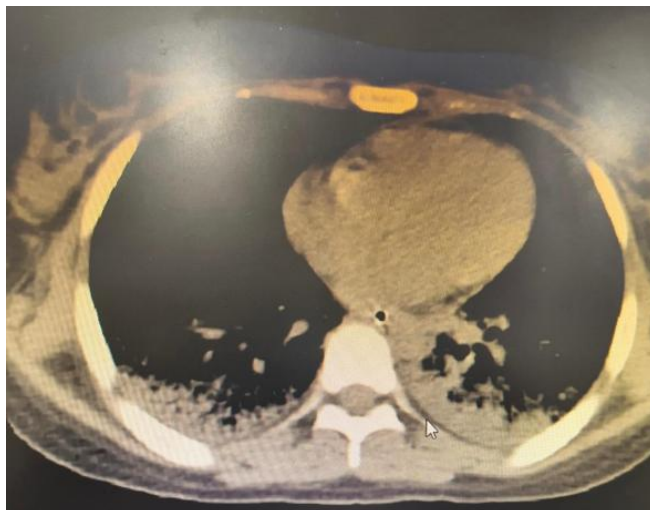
HRCT thorax showing reticulonodular changes and fibrosis
